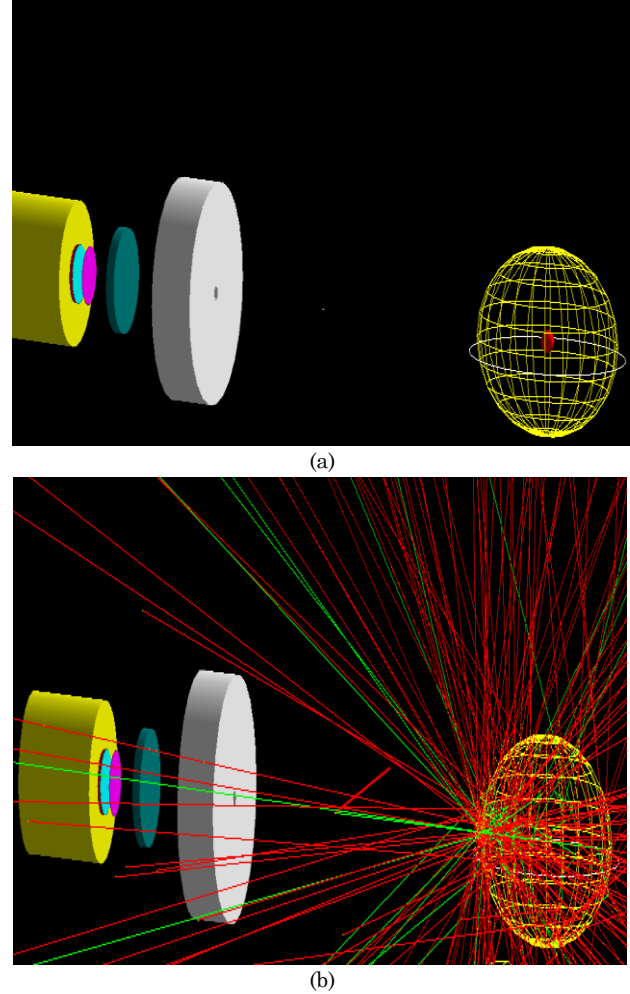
Radiotherapy for a brain tumor using the Geant4 Monte Carlo model. The green lines define secondary X-rays, and the red lines define secondary electrons. (a) Geometry of tumour (red color) localized, (b) Compilation of 107 photons X-rays at the center of head
